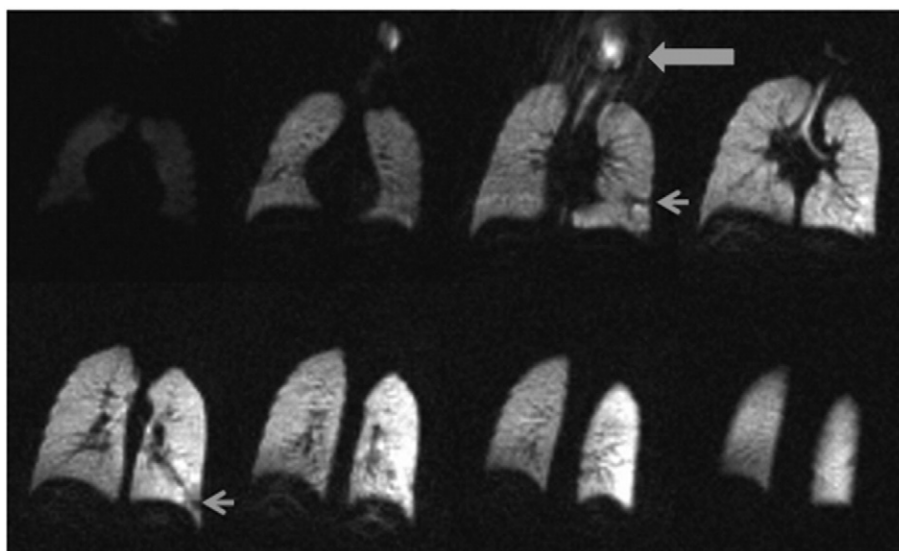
HHe coronal MR images of a 3-year-old non-sedated, unrestrained child with asthma. Small focal ventilation defects are present in the left lower lobe (arrows). Motion artifacts are seen adjacent (inferior) to the diaphragm and surrounding the HHe in the pharynx and hypopharynx (long arrow).
